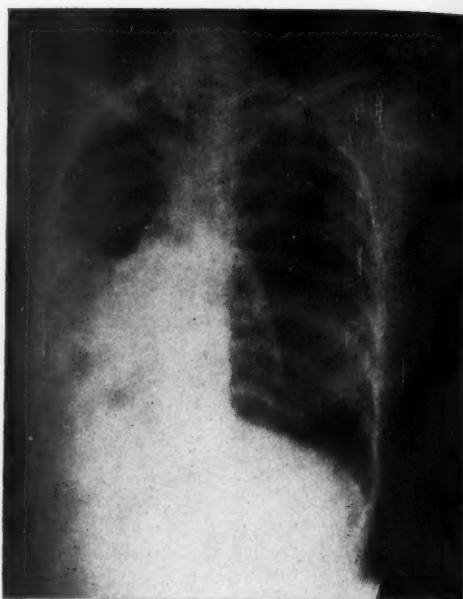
(A403891). Intrathoracic changes following intensive roentgen therapy directed to the thorax. The lesion has a definite fibrotic appearance in the roentgenogram.
